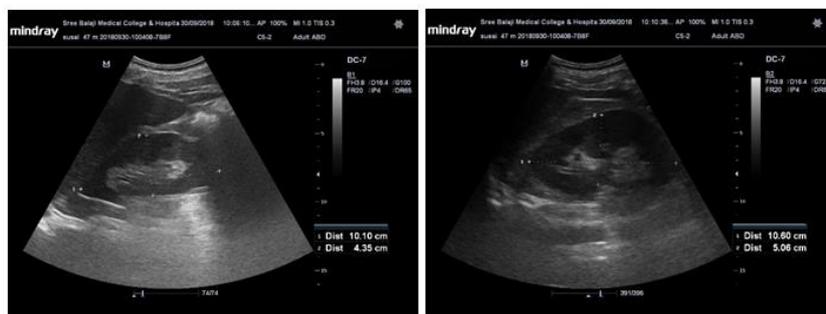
shows ultrasound image of the measurement of right and left kidney lengths
